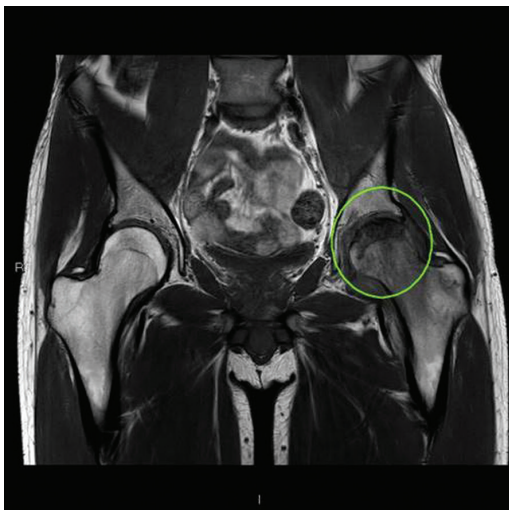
Hypointense T1 signal in superior left femoral head with subtle subchondral collapse on MRI.
